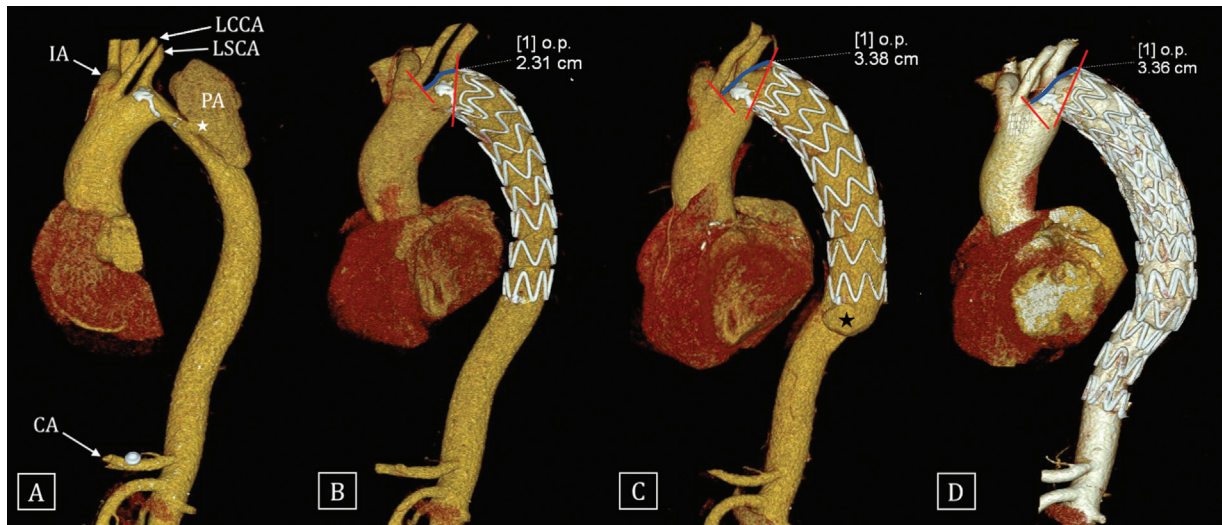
Volume rendered computed tomography (CT) images show the evolution of a case with descending thoracic aorta (DTA) pseudoaneurysm (asterisk in A) treated by thoracic endovascular aortic repair (TEVAR). Stent graft was deployed in proximal landing zone 3 with technical success (B). The follow-up CT after 8 months (C) of the procedure showed significant proximal migration of the stent graft (~11 mm) and development of pseudoaneurysm (asterisk in C) at the distal end of stent graft. This was treated with another overlapping stent graft with the exclusion of pseudoaneurysm.
